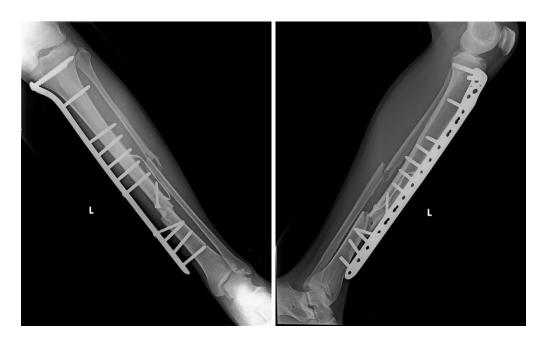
AP and Lateral radiograph of left leg at 18 weeks follow up
